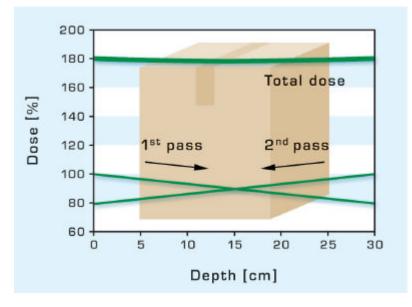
Dose distribution for double sided X-ray treatment
